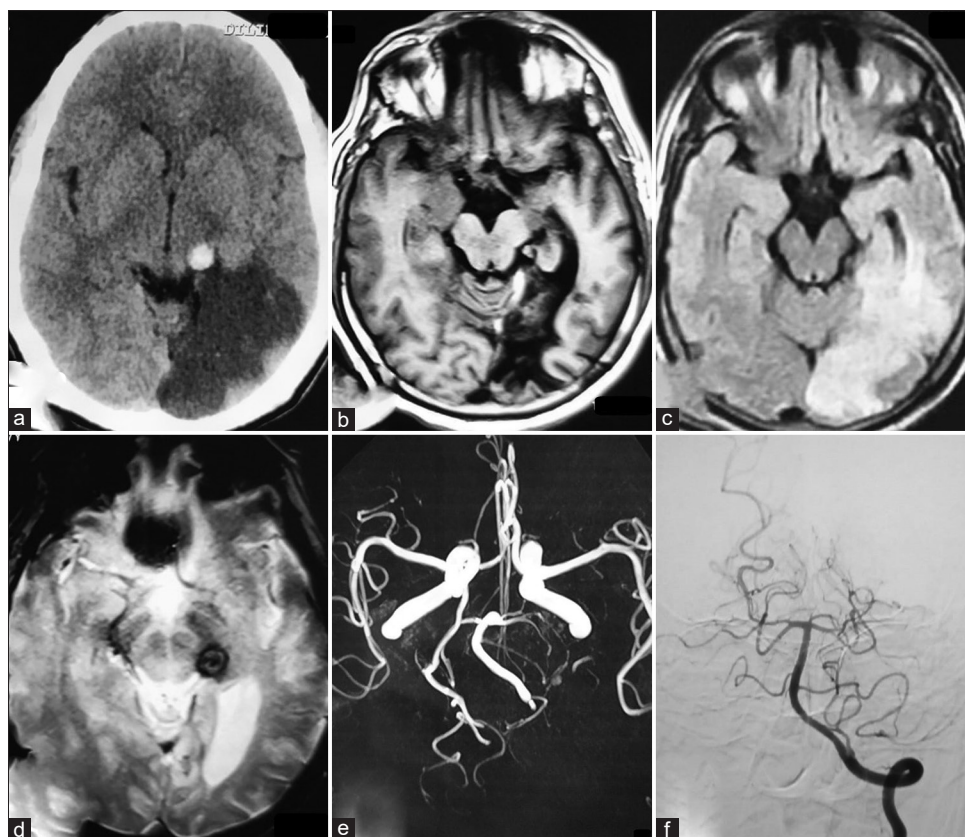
Nonenhanced brain CT (axial section) showing a hyperdense blot in the left ambient cistern with a well-demarcated hypodensity conforming to the left posterior cerebral artery (PCA) territory, suggestive of an infarct (a); interval nonenhanced magnetic resonance imaging (MRI) scan T1 axial sequence revealing an iso-hypointense globular structure in the left crural cistern with associated hypodensity in the distribution of left PCA territory (b); interval nonenhanced MRI FLAIR axial sequence showing hyperintensity in the same distribution (c); interval nonenhanced MRI GRE sequence revealing an ovoid hypointense signal change. The preliminary CT head and the interval T1 and GRE sequences most likely represent the dissected left PCA (P3) segment, which resulted in the PCA infarction (d); MR angiography time of flight (TOF) sequence revealed faint visualization and cutoff of the left PCA beyond the distal P2 segment (e); left vertebral digital subtraction angiography (DSA) confirming the MRI TOF imaging findings (f)
